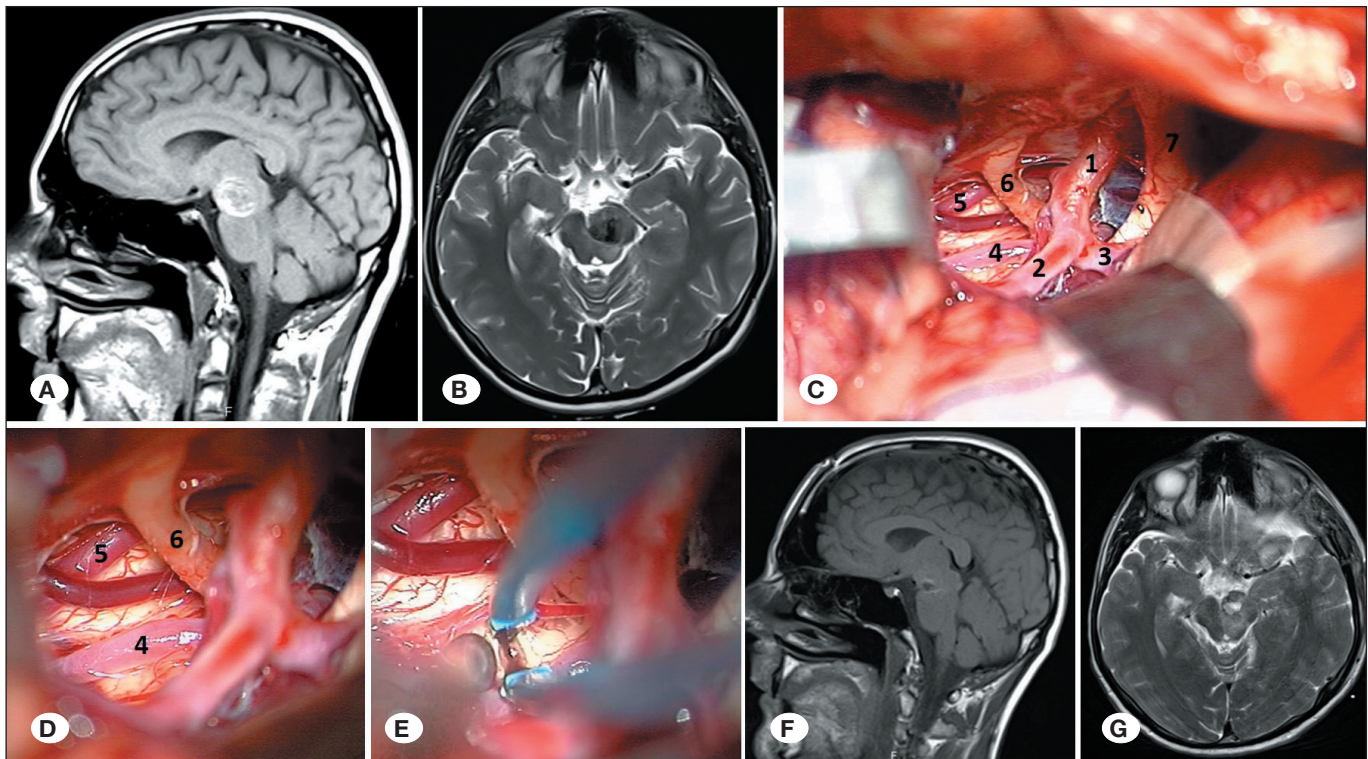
Case #11. A) T1-weighted sagittal magnetic resonance imaging (MRI) shows ventral mesencephalic cavernoma, B) T2-weighted axial MRI, C) intraoperative picture after fully splitting the left Sylvian fissure (1: ICA, 2:MCA, 3:AI, 4: Post. Cerebral Artery, 5: Sup. Cerebellar artery, 6: The oculomotor nerve, 7: The optic nerve), D) view of the surgical field with higher magnification, E) a small incision in the perioculomotor safe entry zone and drainage of the hematoma, F) postoperative T1-weighted sagittal image, G) postoperative T2-weighted axial image.
